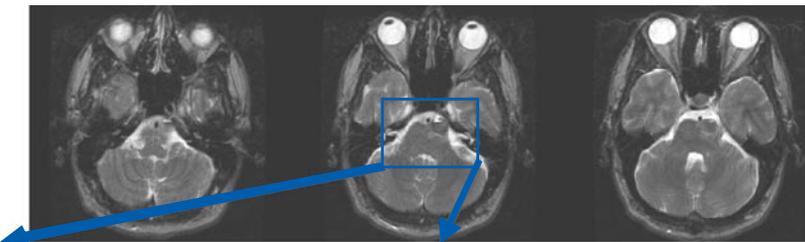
(and inset). T2-weighted images on this MRI obtained when the patient was admitted reveal a heterogeneous mass just anterior to the 7–8 nerve complex.
